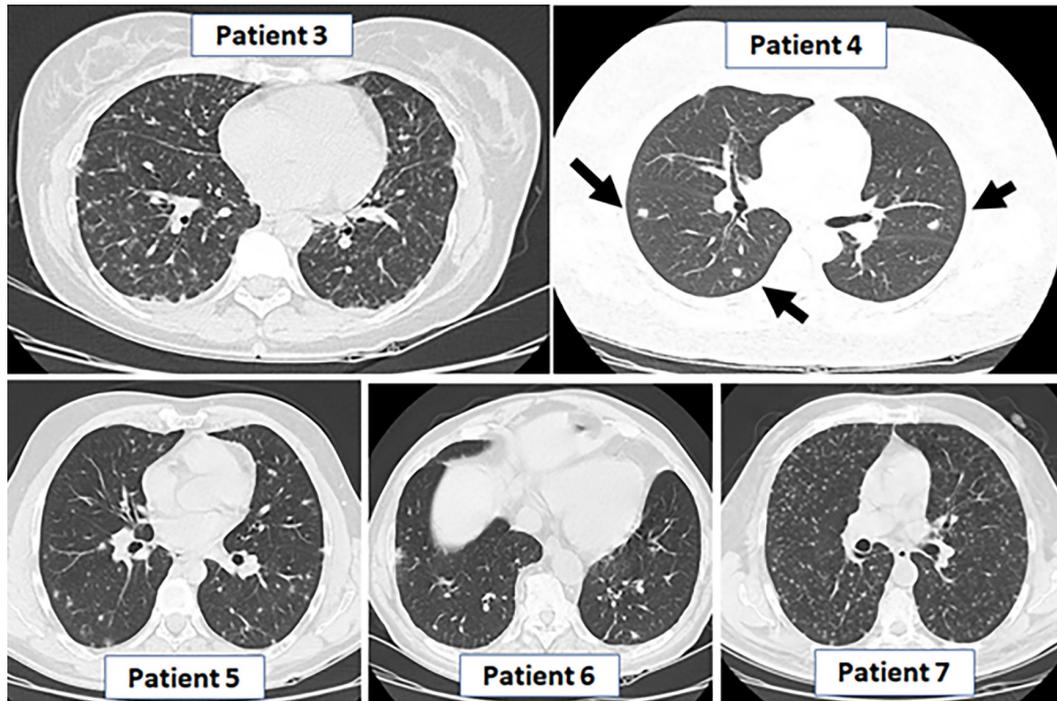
Chest CT of five patients showing the pattern of a diffuse micronodular infectious process in the lungs (ground-glass opacities). Arrows show the presence of peripheral micronodules.
